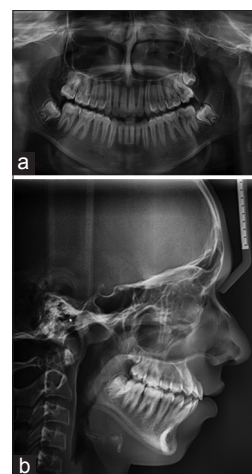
Post treatment. (a) Orthopantomogram. (b) Lateral cephalograph
